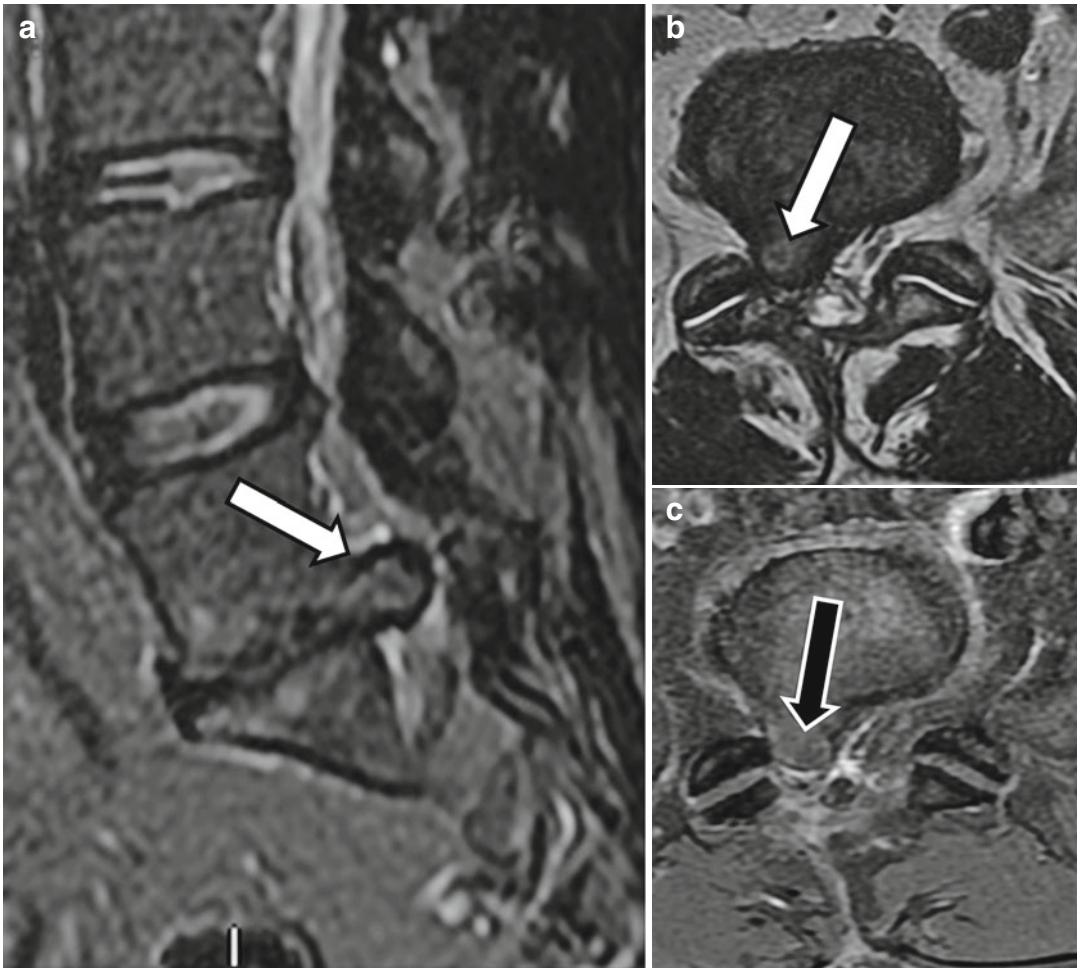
A 47-year-old female 9 months following L5-S1 microdiscectomy with recurrent right-sided radicular pain. Sagittal STIR (a) and axial T2-weighted
